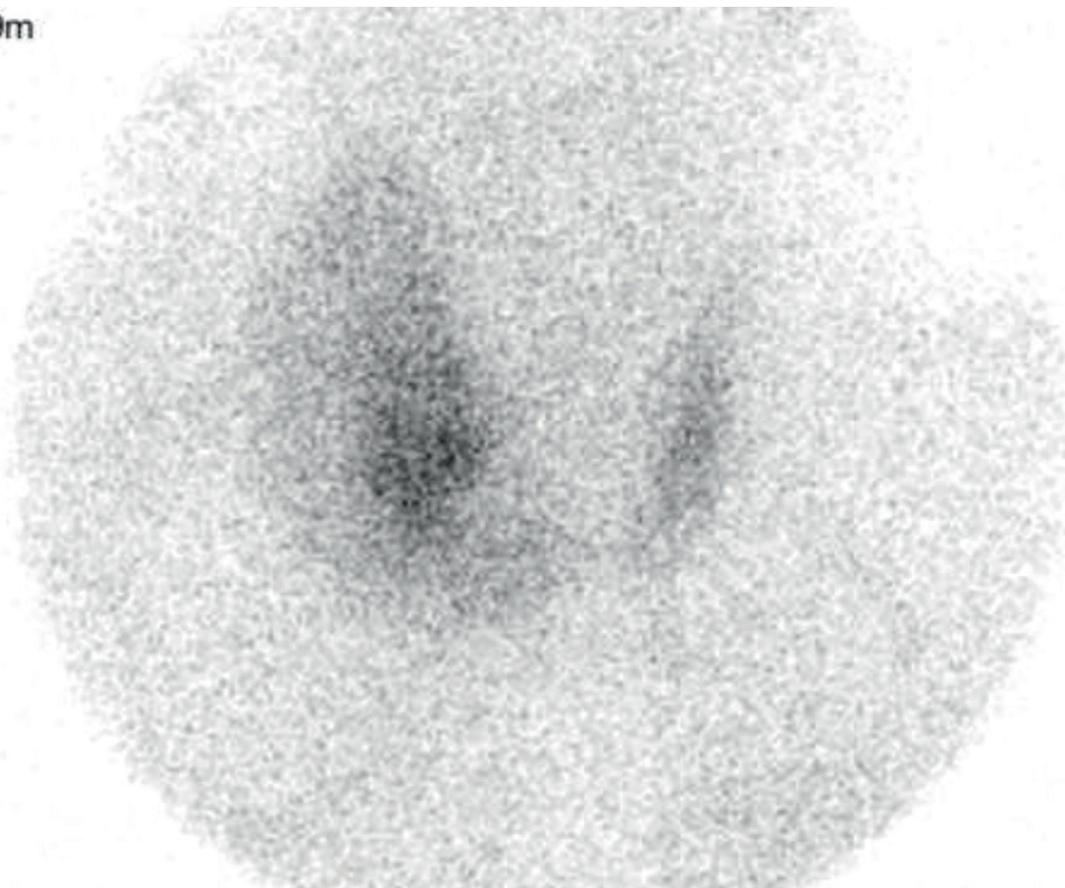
99mTc-Sestamibi scintigraphy of the thyroid (anterior view) showing increased uptake central in the right thyroid bed.
